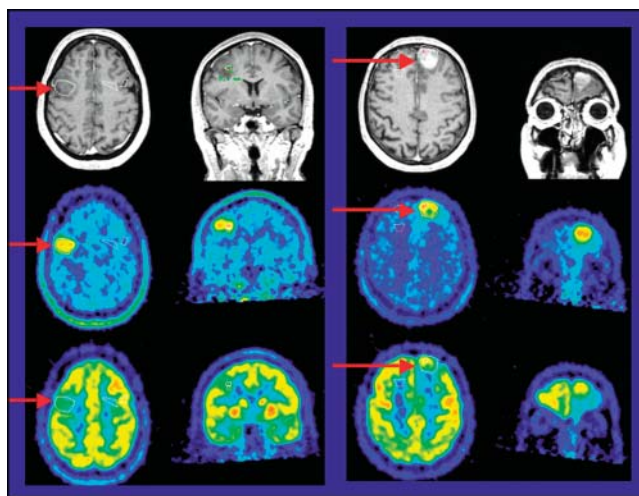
Images acquired in patients with low-grade (left) and high-grade (right) gliomas with MR (top row), ^{18}F -FET PET (middle), and double-tracer ^{18}F -FET/ ^{18}F -FDG PET (bottom).
